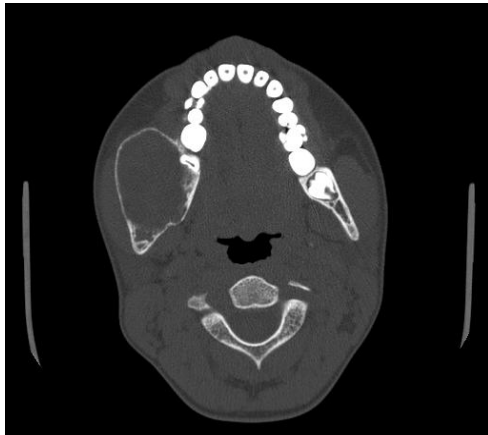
cone beam CT axial view shows bicortical expansile lesion on right side of mandible.
